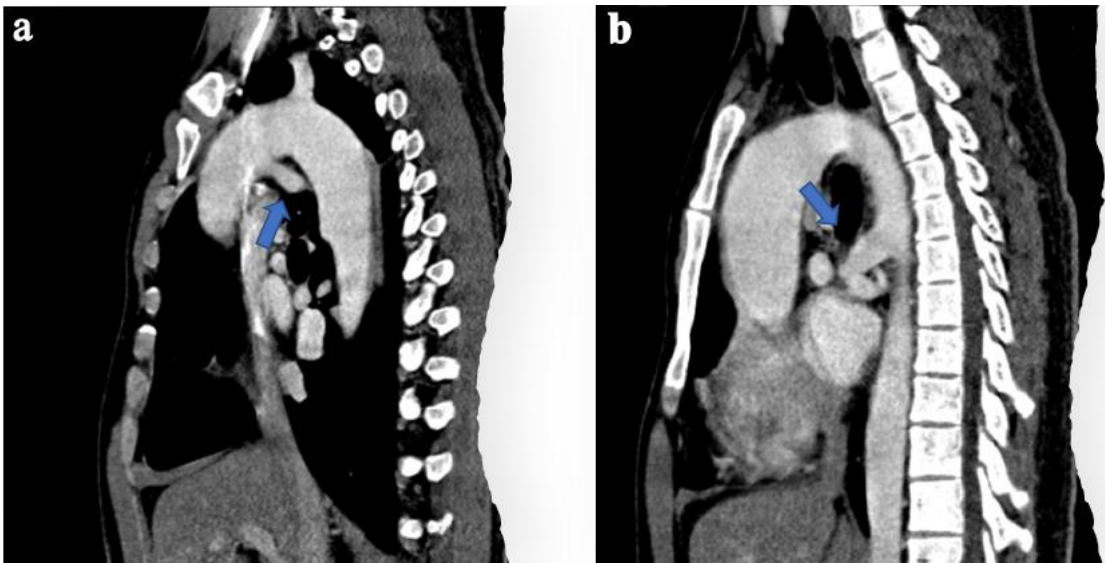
CTA showed pulmonary valve atresia, left lung was supplied by mapca from aortic arch (figure 4a), right lung was supplied by MAPCAs of the thoracic aorta (figure 4b) (blue arrow)
